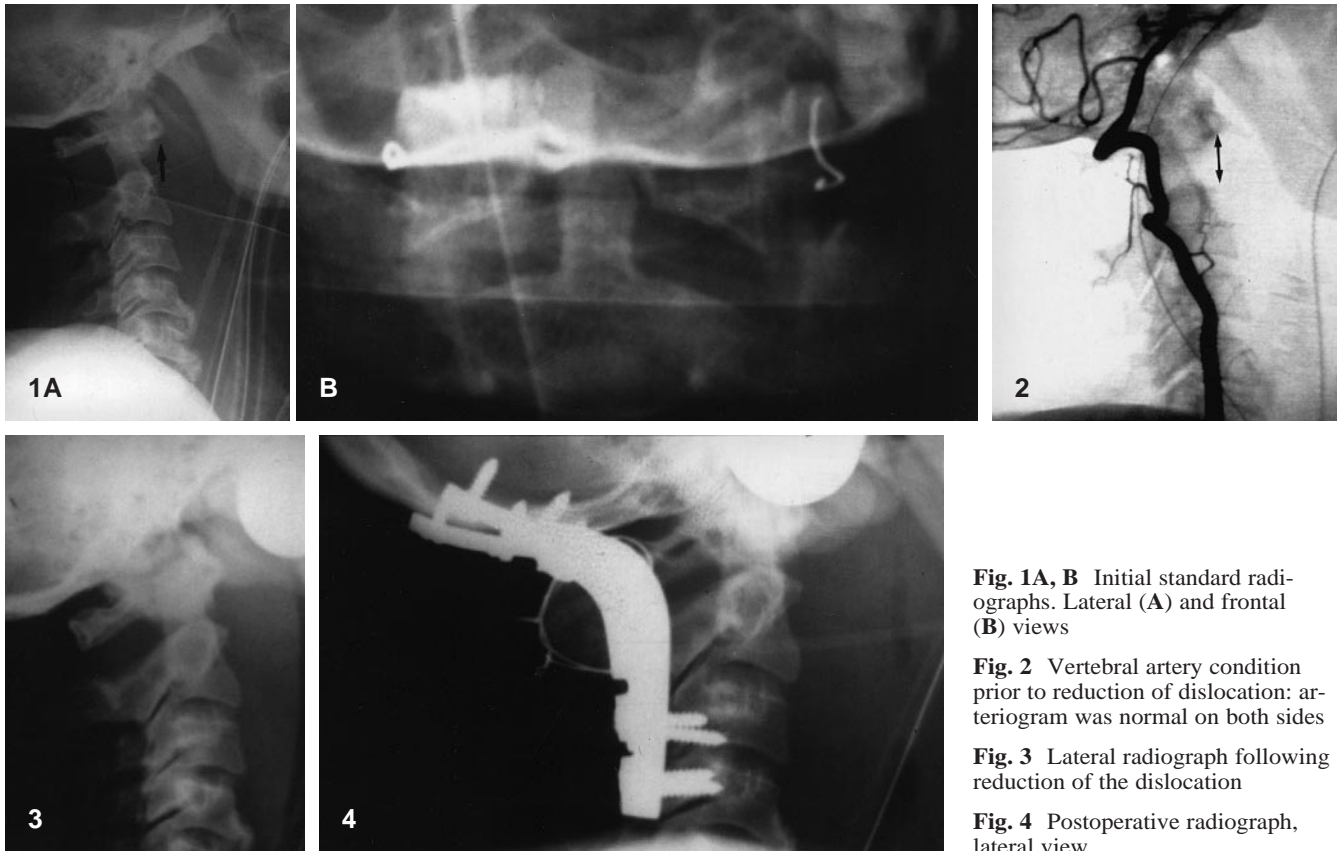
Initial standard radiographs. Lateral (A) and frontal (B) views
